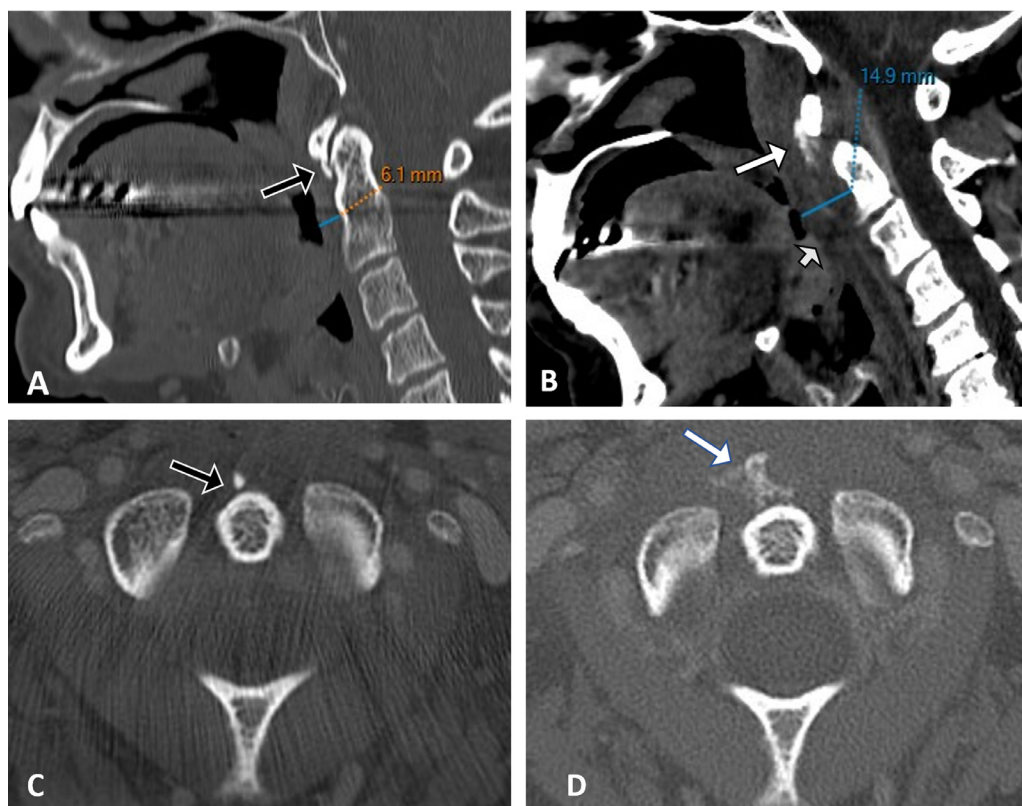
(B) Sagittal, (D) Axial CT computed tomography shows calcifications (White arrow) in the longus colli muscle (LCM) in front of the C1-C2 level with poorly defined margins, a thickening (15 mm) (→) of the prevertebral soft tissue. (A) sagittal, (C) axial of former CT scan performed 3 years ago showed that the calcification (Black arrow) in the LCM was smaller with well-defined margins, and no thickening of the prevertebral soft tissue.
